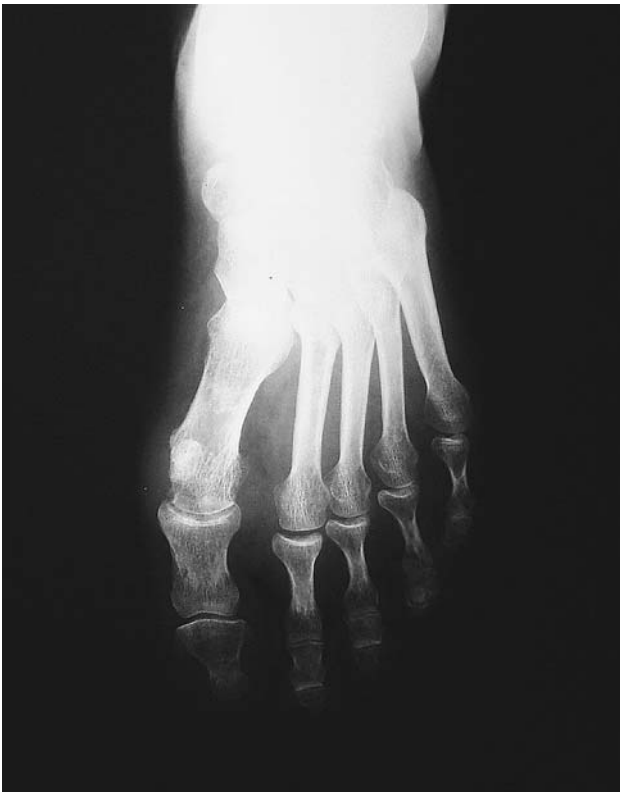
AP X-ray 36 months later postoperatively; good result
